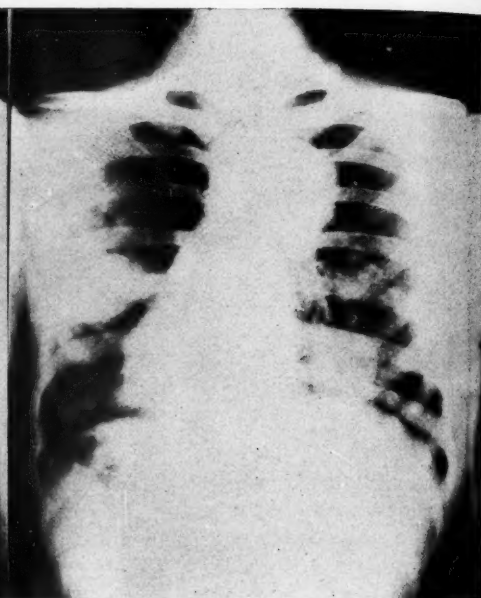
Case 8. Six weeks after taking film shown in Figure 11. X-ray therapy to chest commenced this date. Additional nodule in superior mediastinum.
